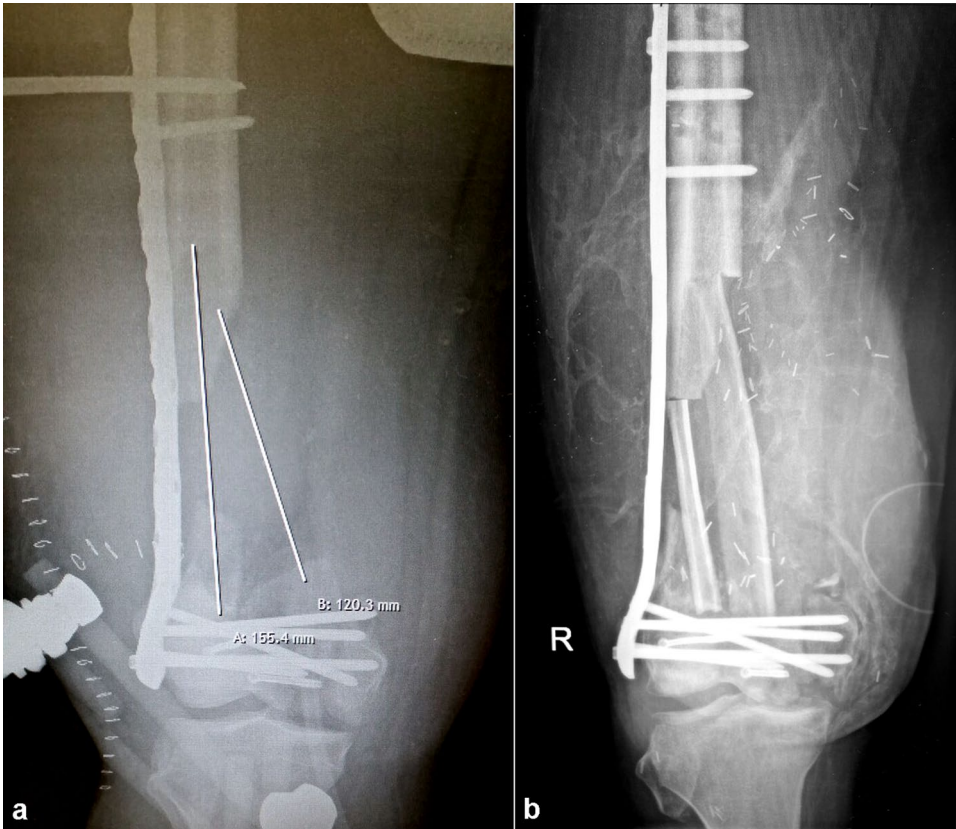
A 35-years-old male polytraumatic patient with supracondylar femoral loss fracture and a 12-cm-long distal femoral defect. X-ray before (a) and after (b). (a) femoral defect; (b) result after 9 months
